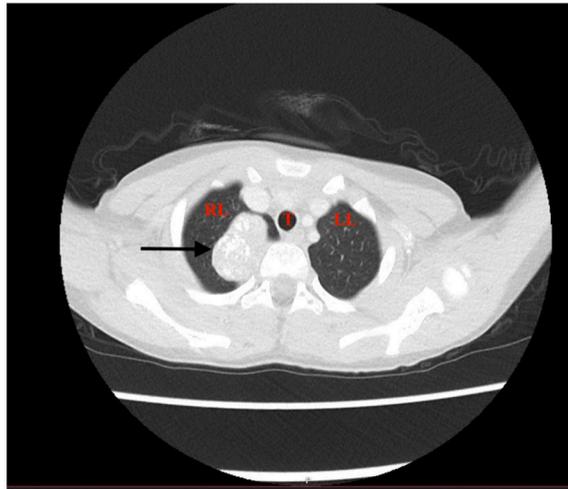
Axial computed tomography (CT) scan. A well-defined mass ($37 \times 25 \times 19.6$ mm) is visible in the upper posterior mediastinum at the level of the TH1–TH2 vertebrae, closely adjoining the inner surfaces of the dorsal ends of the first and second ribs. RL – right lung; LL – left lung; T – trachea; black arrow – mass in the superior part of the mediastinum.
